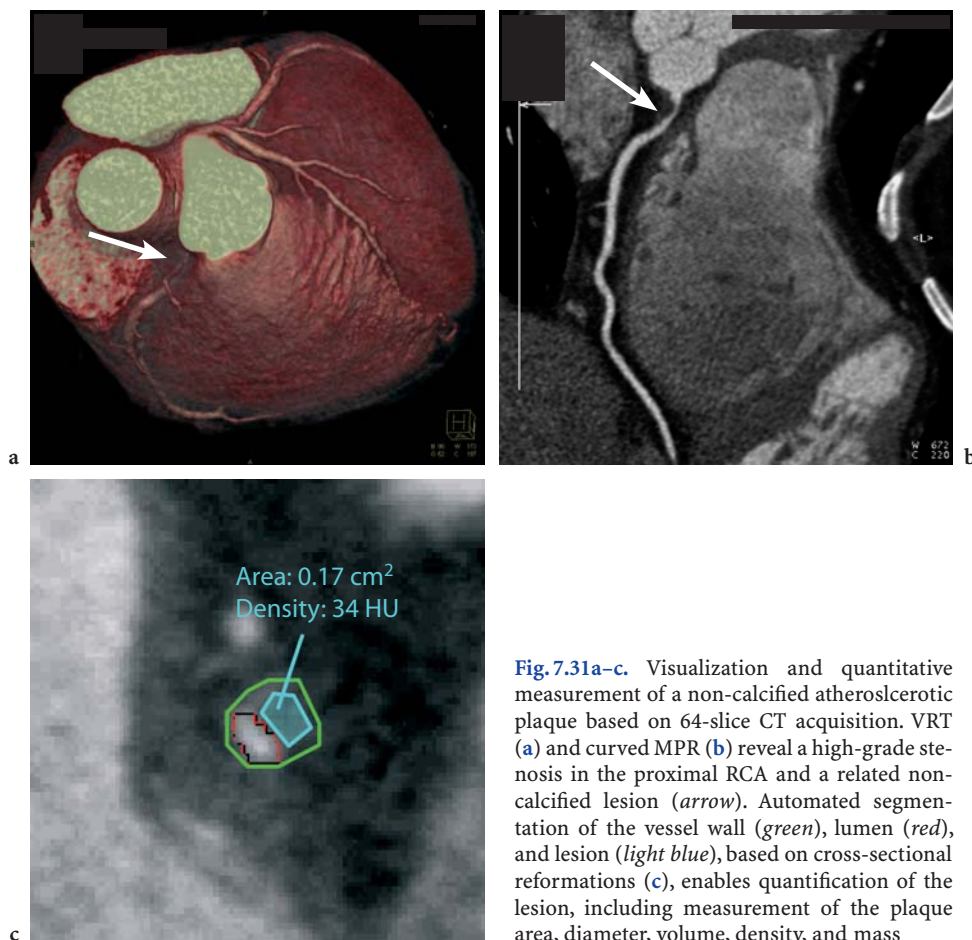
Visualization and quantitative measurement of a non-calcified atherosclerotic plaque based on 64-slice CT acquisition. VRT (a) and curved MPR (b) reveal a high-grade stenosis in the proximal RCA and a related non-calcified lesion (arrow). Automated segmentation of the vessel wall (green), lumen (red), and lesion (light blue), based on cross-sectional reformations (c), enables quantification of the lesion, including measurement of the plaque area, diameter, volume, density, and mass
